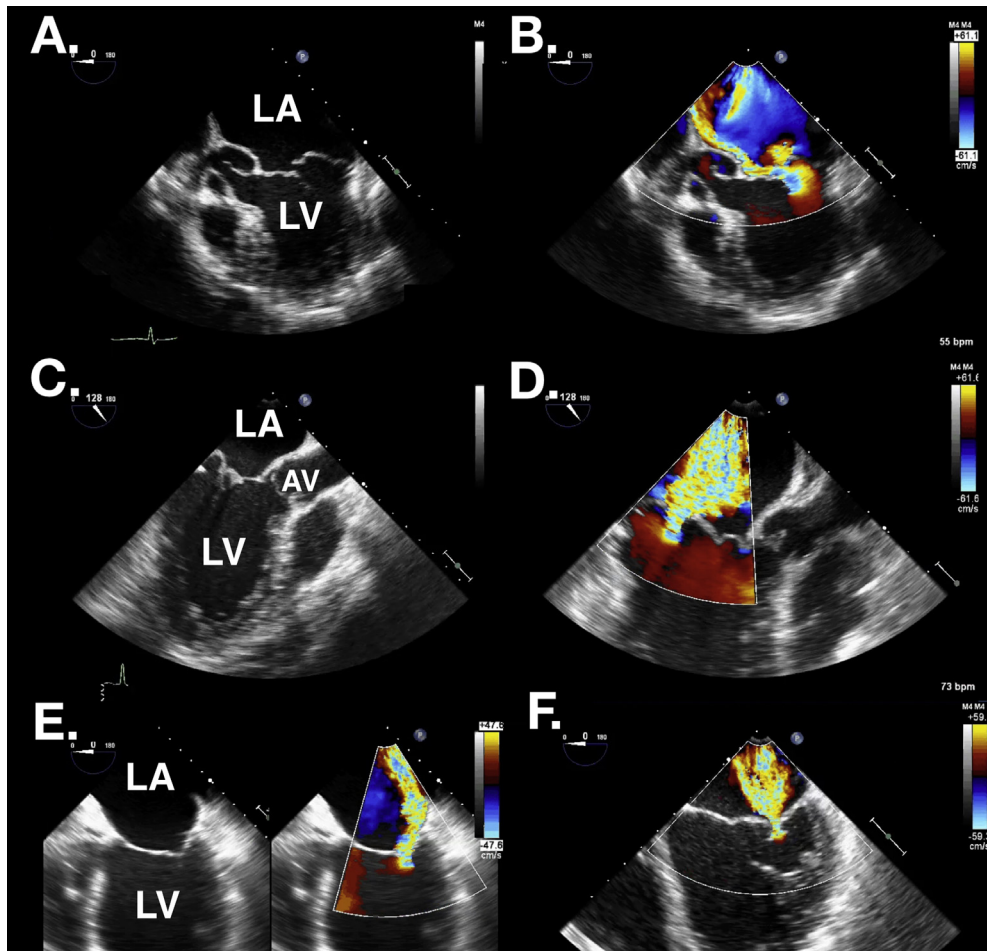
(A) 2D TEE four-chamber view of the MV showing posterior leaflet flail, expanded Carpentier classification excessive leaflet motion type IIa. (B) Corresponding color flow Doppler of the type IIa jet directed away from the flail segment. (C) 2D TEE ME-LAX view of the MV showing billowing prolapse, expanded Carpentier classification excessive leaflet motion type IIb. (D) Corresponding color flow Doppler of the type IIb central jet. (E) 2D TEE four-chamber and color flow Doppler comparison view of the MV showing asymmetric systolic restriction, expanded Carpentier classification type IIIc; the greater restriction of the posterior leaflet leads to a posteriorly directed jet. (F) 2D TEE four-chamber view color flow Doppler of the MV showing symmetric systolic restriction, expanded Carpentier classification type IIIb, and the associated centrally directed jet. AV, Aortic valve. (See associated [Video 3](#), available at www.onlinejase.com.)
